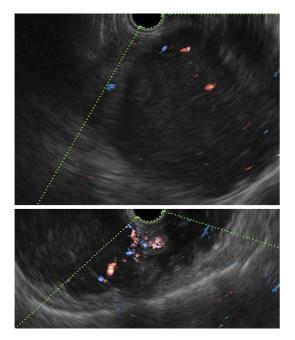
Endoscopic ultrasonography (EUS) at 7.5 MHz. Doppler-EUS at 7.5 MHz depicted hypervascular mass with vascular-enriched submucosa.
